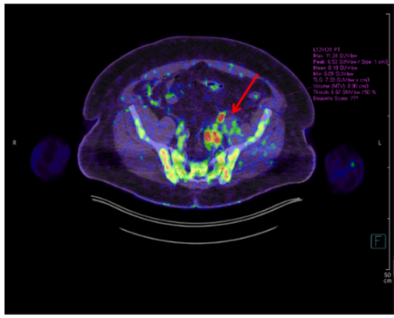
FDG-PET on hospital day 6 revealed increased glucose metabolism in the vessel wall of the left internal iliac artery with a short-segment thrombotic change and posterior extension into the proximal superior gluteal artery, as well as caudal extension into the proximal internal pudendal artery.
